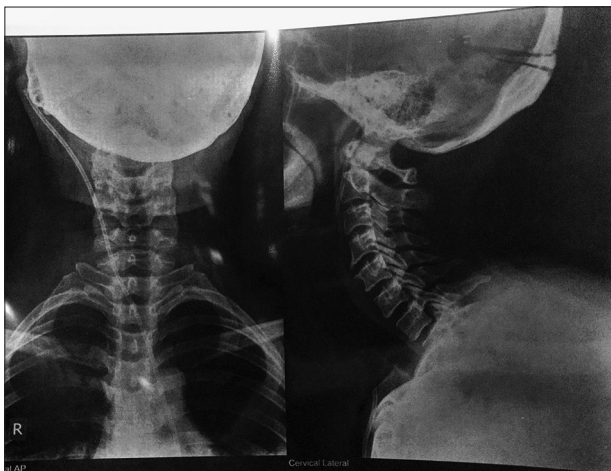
Cervical lateral X-ray showing the ventriculoperitoneal shunt
